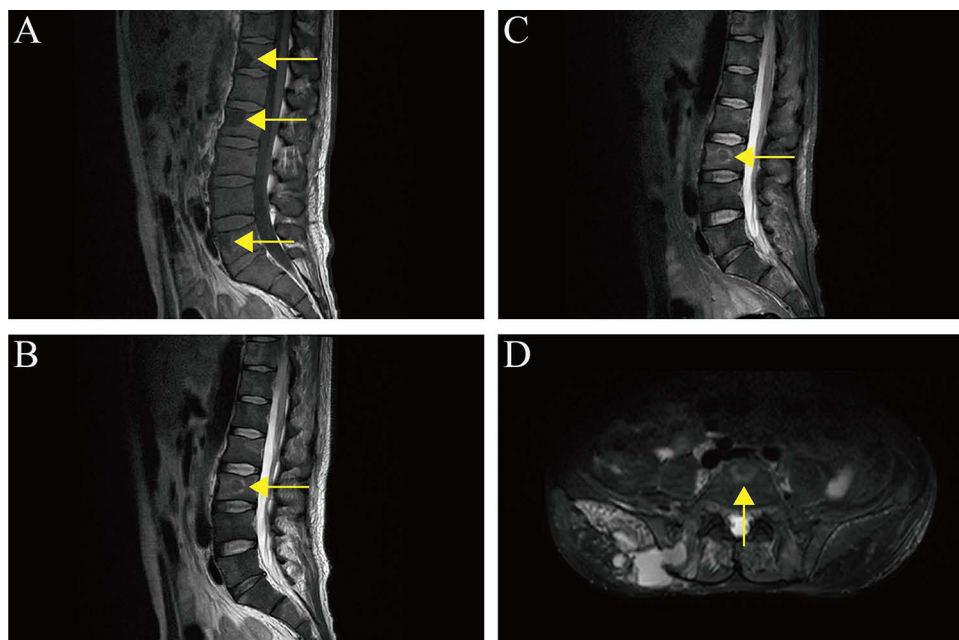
(A–D) Spinal MRI yellow arrows indicate abnormal signals in the thoracic vertebrae, lumbar vertebrae, sacrum and bilateral ilium, and abscess formation around the sacroiliac joint.
